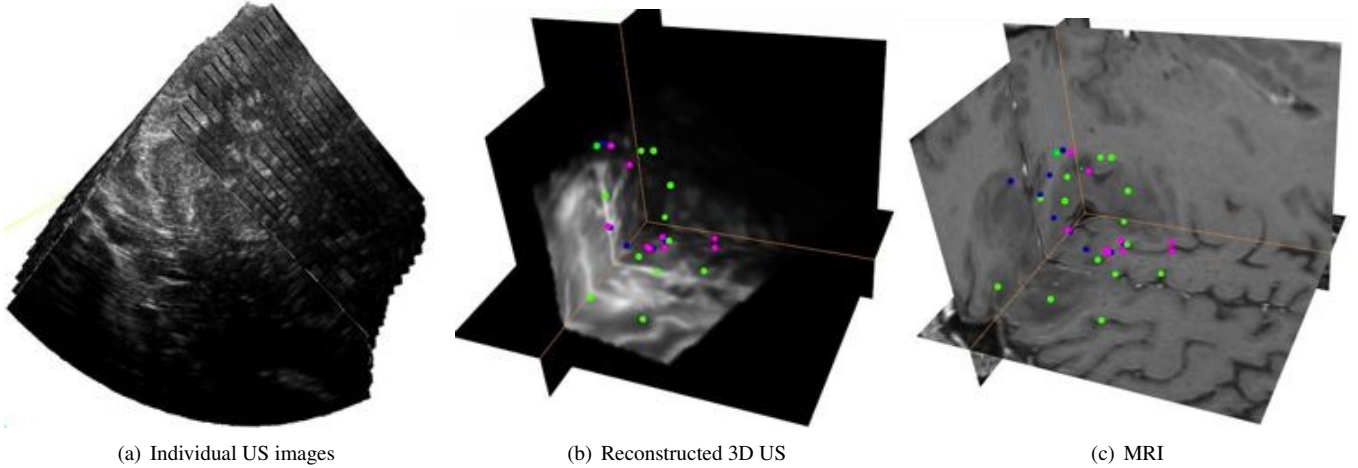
The original 2D US slices and the reconstructed 3D US MR images. In (b) and (c), the landmarks selected by 3 experts are shown. Each of the 3 colors (blue, green and red) corresponds to an expert. The images are from patient 1 in Table 1.
